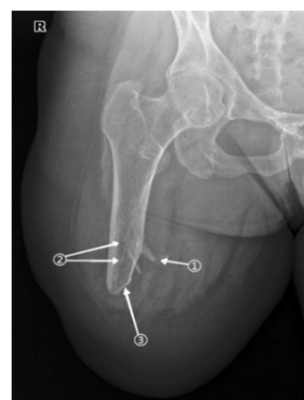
Amputation stump of the right thigh of patient K., 56 years old (8 weeks after amputation). Standard radiography with direct 2x magnification.
